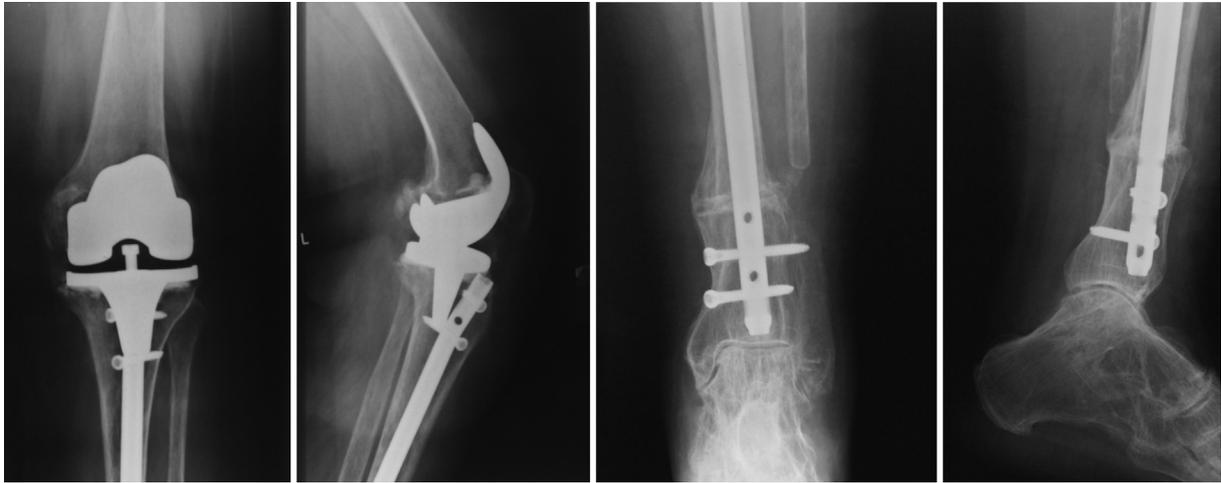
8-year follow-up radiographs of the knee and ankle joint of patient number 1.
